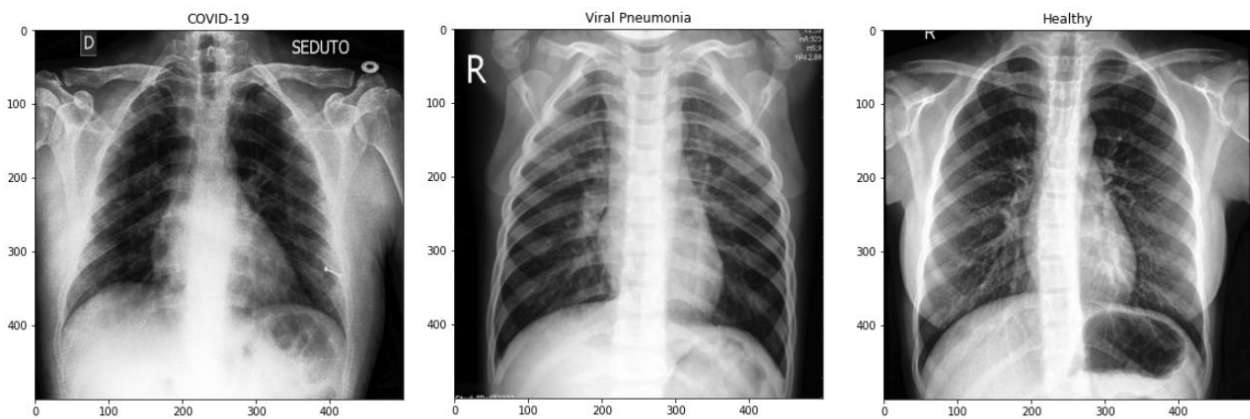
Chest X-ray image of COVID-19, Viral Pneumonia and Healthy patients from the University of Montreal dataset
